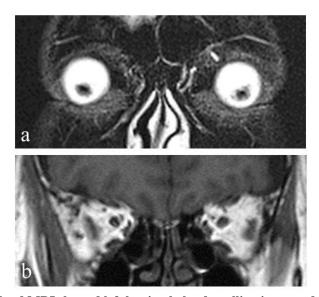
Coronal (a) T2-weighted MRI showed left lacrimal gland swelling improved to normal appearance after steroid treatment. The extraocular muscles were not enlarged (b: coronal T1-weighted MRI)
